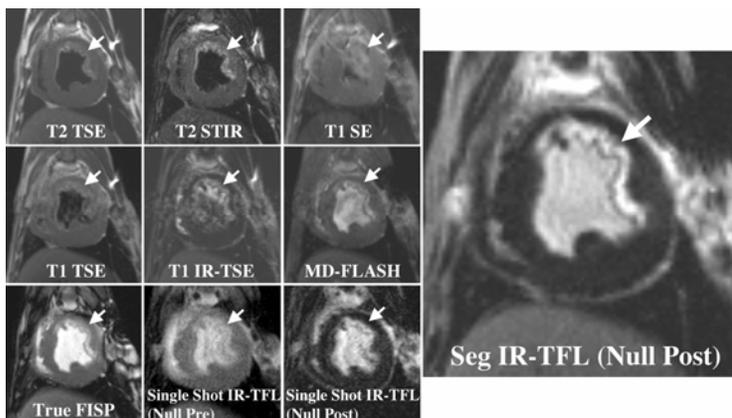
Contrast-enhanced images of the same heart using 10 different MRI techniques. The segmented inversion recovery technique (large image) produced the clearest delineation of the hyperenhanced region (arrows). Reprinted by permission, *Radiology* 2001;218:215-223.
